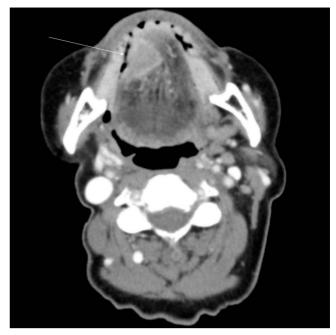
Axial contrast-enhanced CT showing right ventral tongue tumour (white arrow) just reaching the midline.
